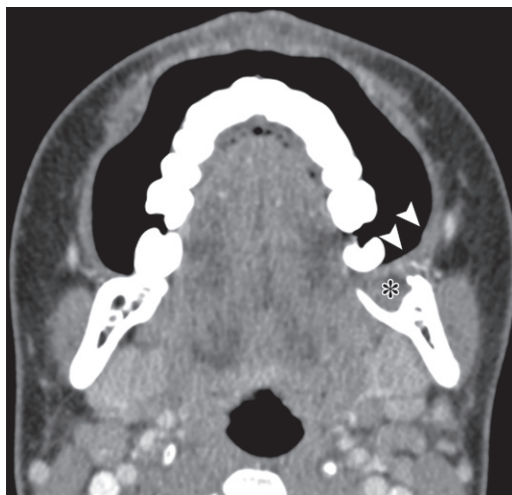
Noncomplicated third molar extraction. Axial contrast-enhanced CT image (soft-tissue window) a few days after a dental extraction shows soft-tissue material filling the alveolar cavity (*), thickening and enhancement of gingival and buccal mucosal surfaces (arrowheads), and mild stranding of the buccal fat space.
